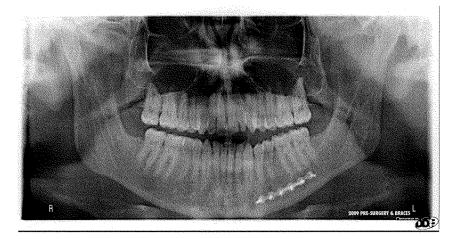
Panoramic X-Ray taken in 2009 before braces or any surgical intervention. Note how healthy the jaw and tooth roots look.
